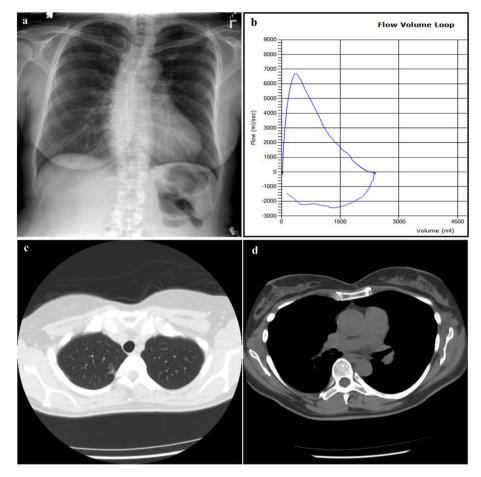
a. Normal CXR; b. Flow volume loop with flattening of inspiratory limb; c-d. CT chest showing bronchiectasis, ascending aorta aneurysm and mild pulmonary artery enlargement.
